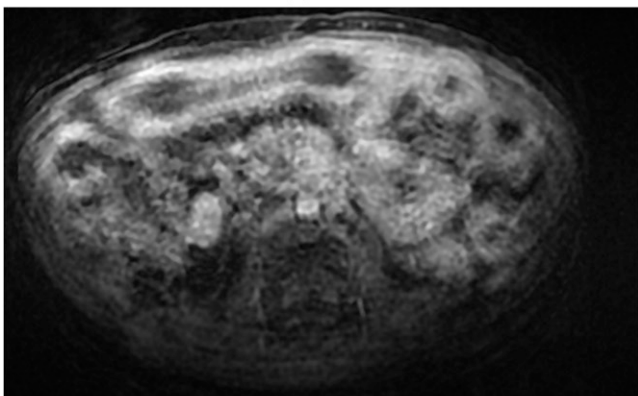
MR enterography in 7-year-old female with Crohn's disease. (a) Axial T_2 single shot fast spin echo shows a long wall thickening (arrowheads) of the small bowel. (b) Axial diffusion-weighted imaging ($b = 1000 \text{ s mm}^{-2}$) shows a hyperintense signal of the small bowel with no artefact. (c) Axial T_1 LAVA fat saturation after gadolinium enhancement shows a sequence with multiple artefacts. The enhancement is less well visualized as compared with DWI (b).
